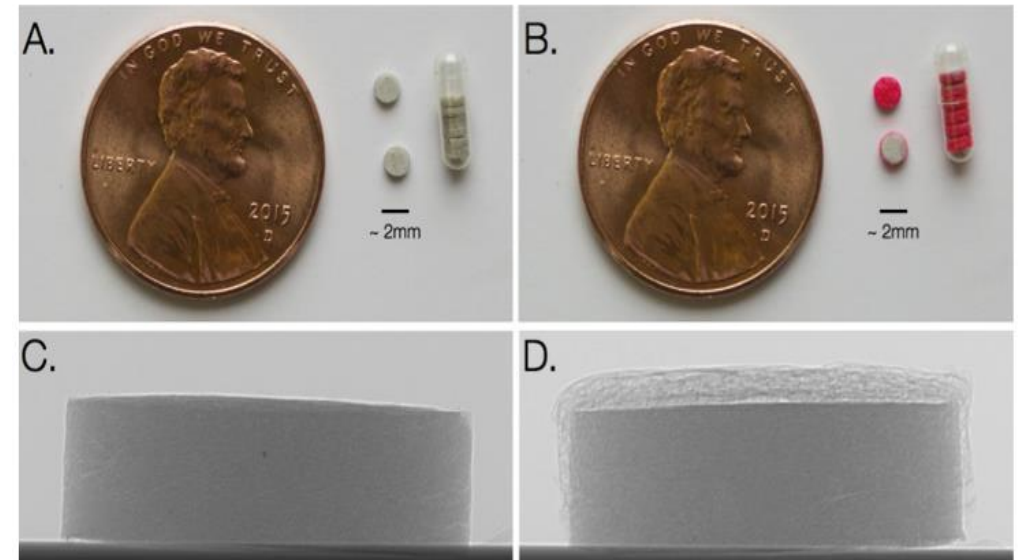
Digital images of (A) uncoated tablets and (B) coated tablets in reference to a penny and filled ($n = 6$) into a size 9 capsule. X-ray Computed Tomography cross-section images of (C) uncoated and (D) coated tablets.
